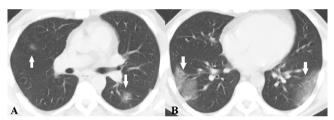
Chest computed tomography showing multiple and bilateral ground-glass opacities, predominantly peripheral (A and B), some with superimposed intralobular septal thickening (B) (white arrows).
